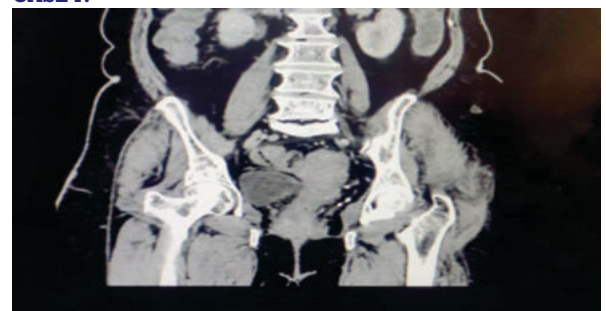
CT coronal image shows asymmetrical
